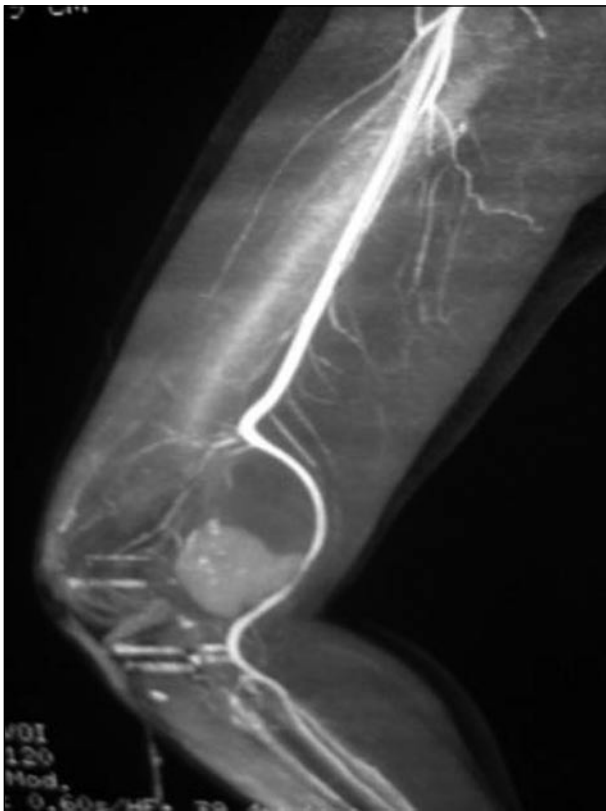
CT-angiogram showing the pseudoaneurysm pushing the popliteal artery posteriorly
